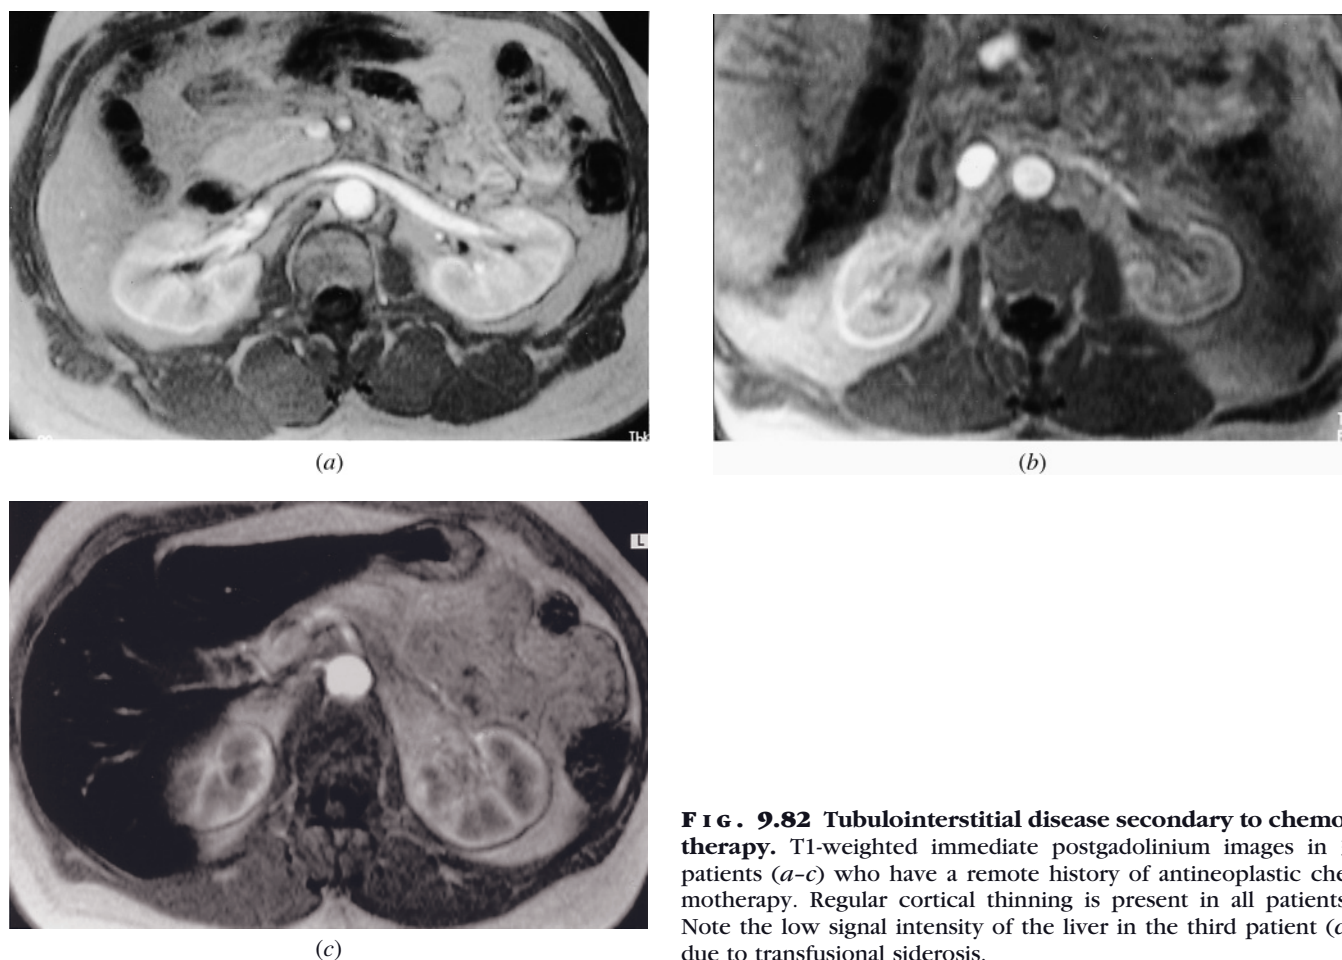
Tubulointerstitial disease secondary to chemotherapy. T1-weighted immediate postgadolinium images in 3 patients (a–c) who have a remote history of antineoplastic chemotherapy. Regular cortical thinning is present in all patients. Note the low signal intensity of the liver in the third patient (c) due to transfusional siderosis.
